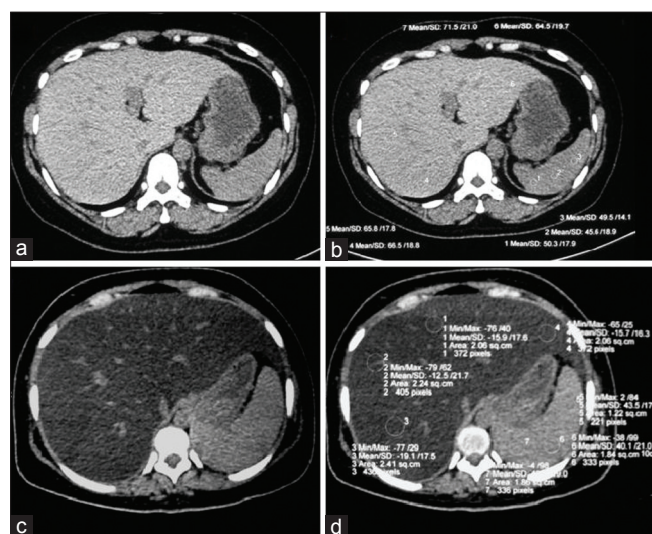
CT for detection of liver fat. Image shows (a) normal liver with attenuation greater than spleen on visual analysis (b) multiple ROIs for measurement of attenuation of liver and spleen, mean hepatic attenuation is 67 HU and mean splenic attenuation is 48.5 HU, hence, liver attenuation index LAI is 18.5 HU which is normal (c) diffuse fatty infiltration of liver with hepatic attenuation markedly less than the spleen (d) multiple ROIs show mean hepatic attenuation of -15.8 HU and mean splenic attenuation of 42.5 HU with LAI of -58.3 HU suggestive of marked fatty infiltration of liver
